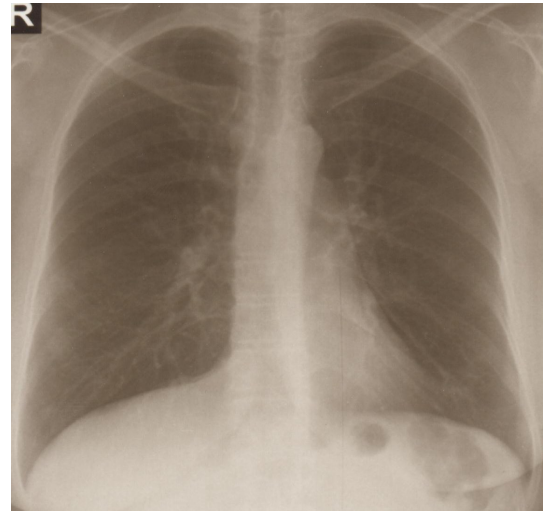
Chest X-ray. COPD. Female age 52
